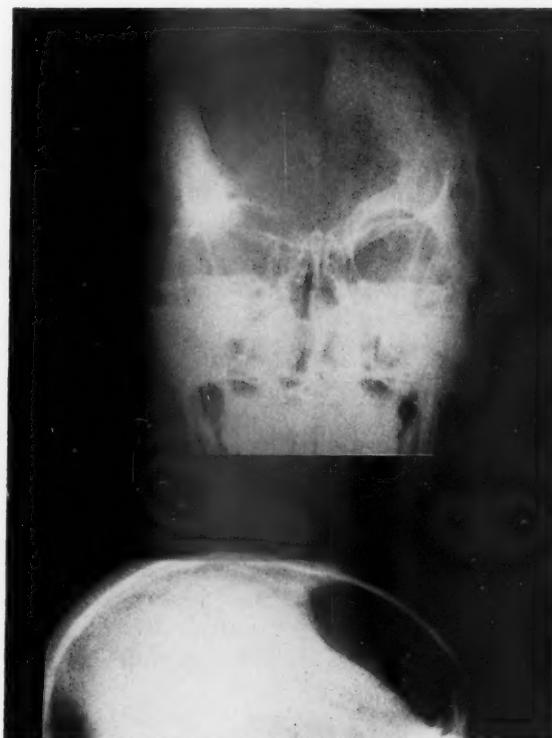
X-rays taken postoperatively showing defects in bone (operative). A. A-P view. B. Lateral view.
